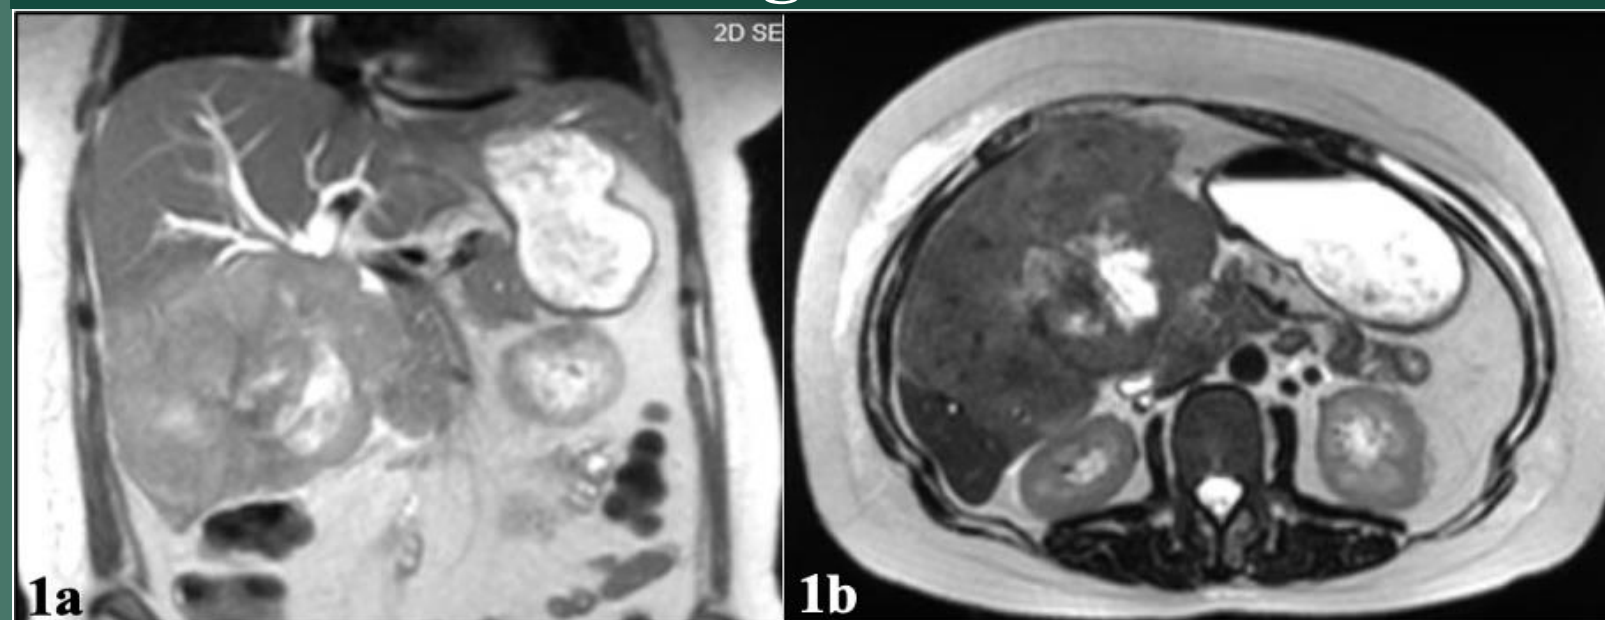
MRI showing heterogeneous mass with a large necrotic center involving the right and left hepatic lobes, common hepatic duct, and proximal common bile duct as well as the ascending colon. 1b: MRCP showing Intrahepatic and extrahepatic biliary ductal dilatation.
